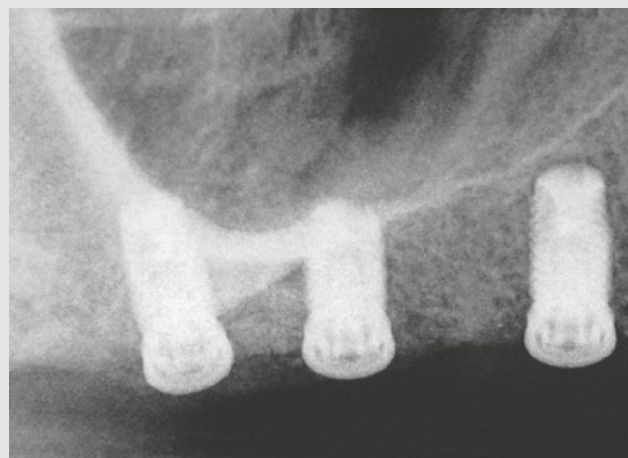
Intraoral radiographic control after osseous integration of the implants (13 months after sinus augmentation).
